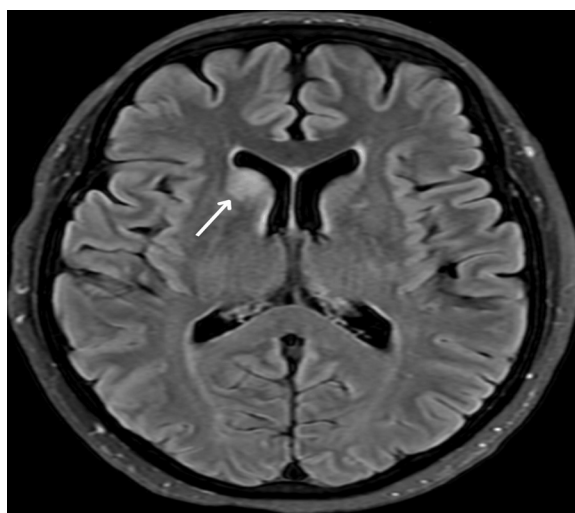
Axial FLAIR MRI of the brain reveals a 1-cm hyperintense lesion in the right caudal region (arrow).
